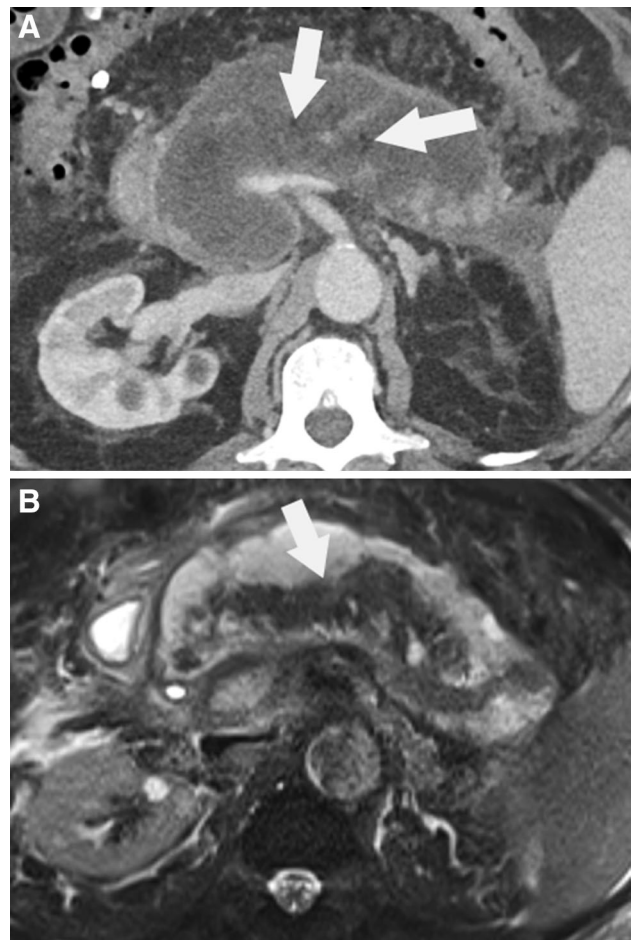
78-year-old man with severe biliary necrotizing pancreatitis. A Axial contrast-enhanced CT image obtained shows a large intra-pancreatic collection occupying almost the entire pancreas with sparing of the part of the pancreatic head and tip of the tail most consistent with walled-off necrosis (WON). Small globules of fat (arrows) are visible within the collection. B Axial T2-weighted MR image obtained within 3 days of the CT demonstrates large intra-pancreatic collection showing areas of fat and debris from pancreatic necrosis (arrow).
